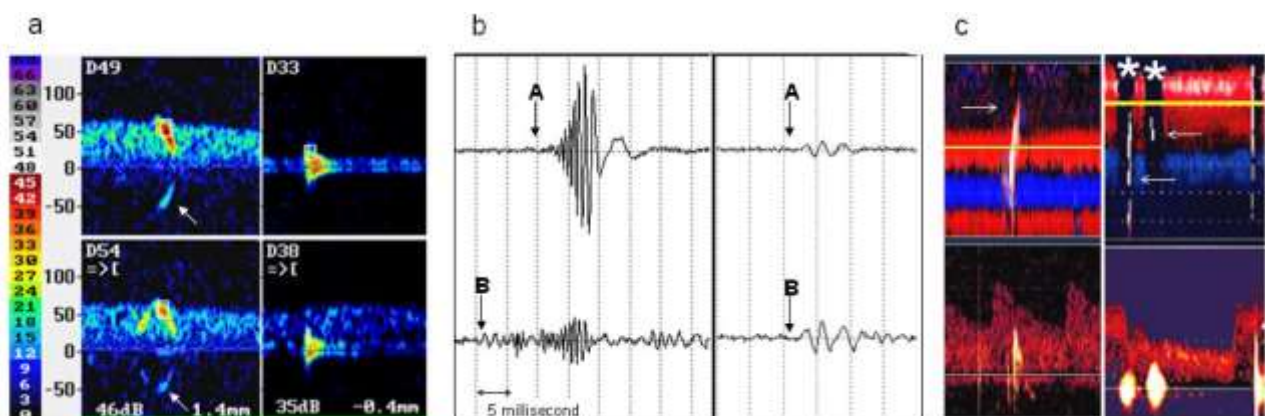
a: Spectrogram appearance of a MES and a cable movement artifact with dual-gate technology is displayed (on the left and right, respectively). MES signal shows lambda sign (white thin arrows), unidirectionality and frequency modulation while artifact is bidirectional. b: Analysis of raw Doppler provides more understanding about this technology. There is a time lag (A-B) of 8 milliseconds between the onset of the two raw signals denoting movement of the MES (on the left). Velocity of this MES was calculated as 41 cm/sec, which is almost equal to that provided by the system (45 cm/sec). In contrast, artifact signal appeared simultaneously in two depth (A-B=0). c: M-mode tracking demonstration of a MES shows characteristic bright tractus with a slope (open white arrow) indicating its movement distally. In contrast, an artifact caused by jaw clenching causes a straight tract with a signal void area typically surrounding it (white star).
